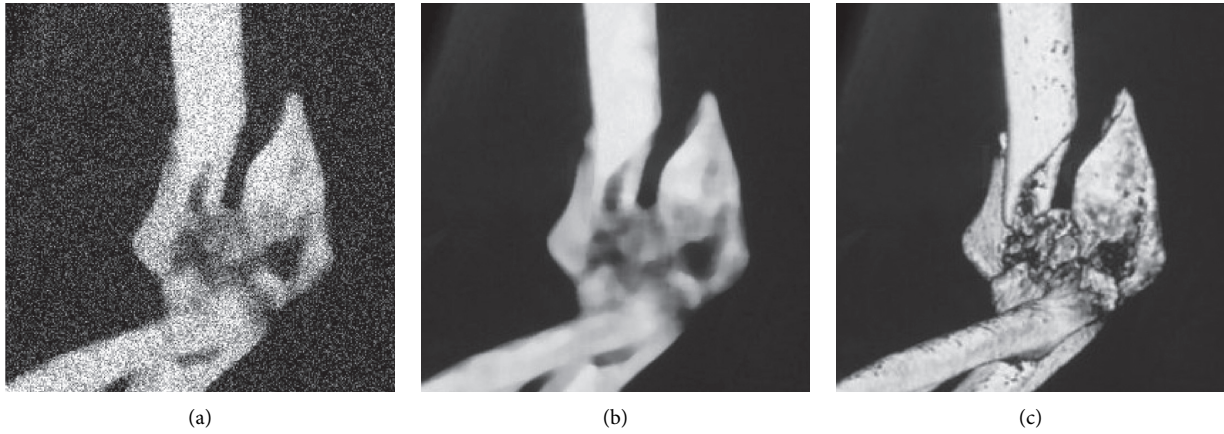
Visual comparison of elbow CT images optimized and processed in different ways. (a) original elbow CT image; (b) routine optimization of elbow CT image; (c) BPF algorithm optimization of elbow CT image.
